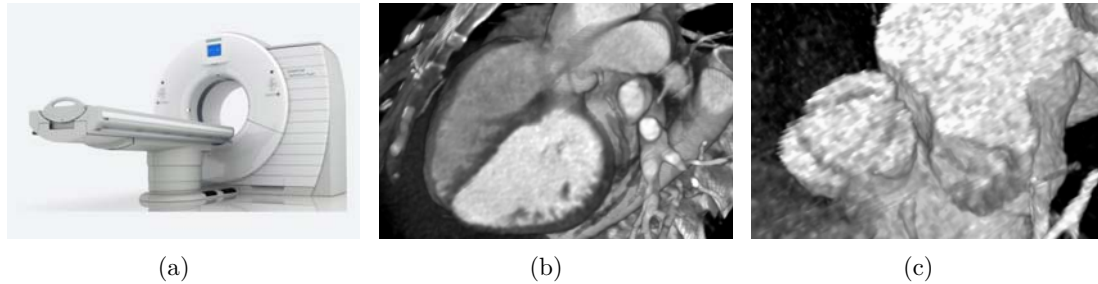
(a) CT - SOMATOM Definition Flash, Siemens Healthcare, Forchheim, Germany. (b) Complete heart scan with contrast on the left side. (c) Volumetric reconstruction of the aortic valve clipped at the valvular sinuses level.
